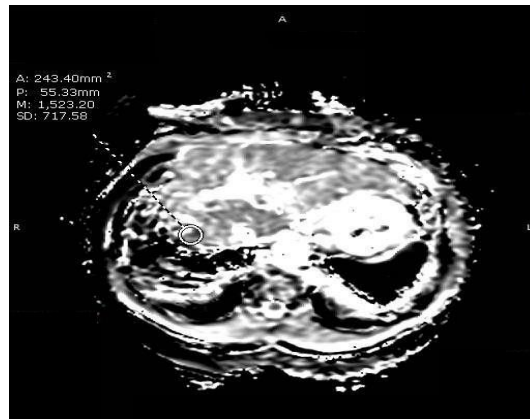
68 years old female patient with liver cirrhosis and HCV + VE underwent TACE of left hepatic lobe lesion segments II focal lesion. Dynamic MRI with diffusion weighted study and ADC mapping was done 3 months after embolization. (A) Axial arterial phase image showing no enhancement (B) Axial delayed phase image showing delayed washout , (C) the lesion showing no restricted diffusion on (DWI),(D) ADC mapping and ADC value decreased 1.2×10^{-3} denoting well ablated.
